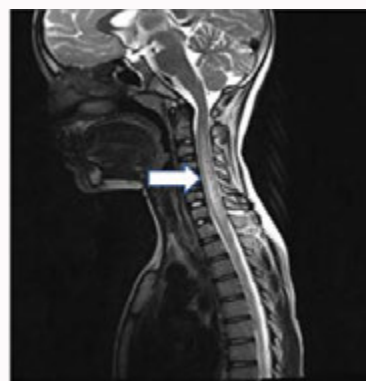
MRI spine showing hyperintensities extending from C2-D6 segment of spine.
